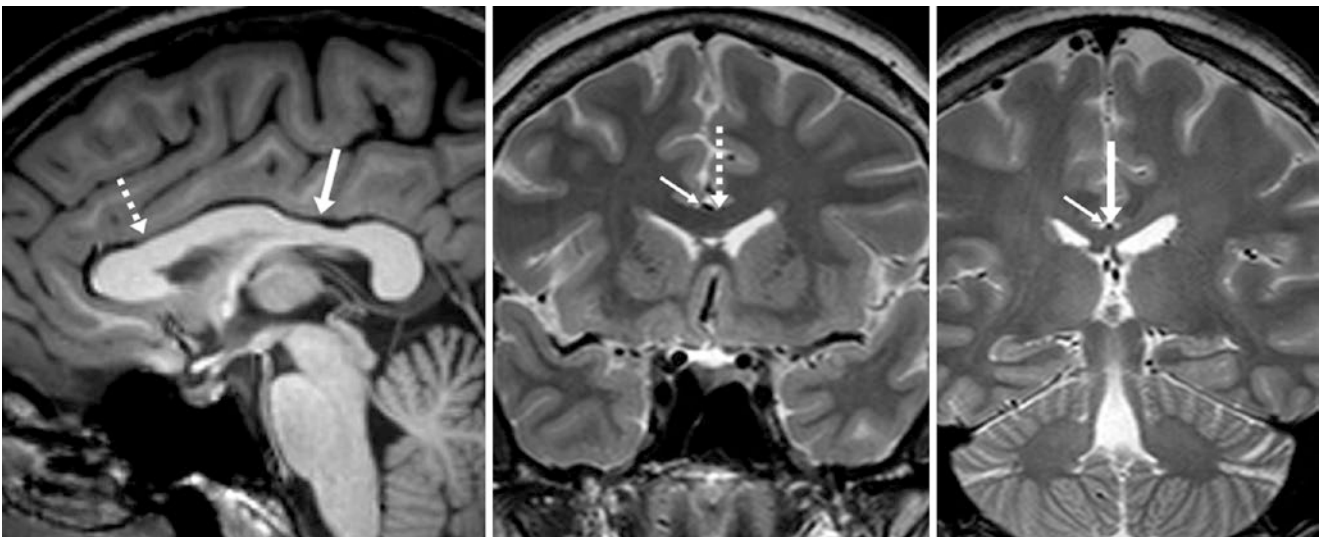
A 28 year old with a normal isthmus (*arrows*) shown on a 3T MRI sagittal T1WI (*left*). Coronal T2WIs through the anterior body (*middle*) and isthmus (*right*) show the disparate thickness between the isthmus (*arrows*) and the anterior body (*dashed arrows*). Indentation by the pericallosal arteries (*thin arrows*) may contribute to the apparent thinning
